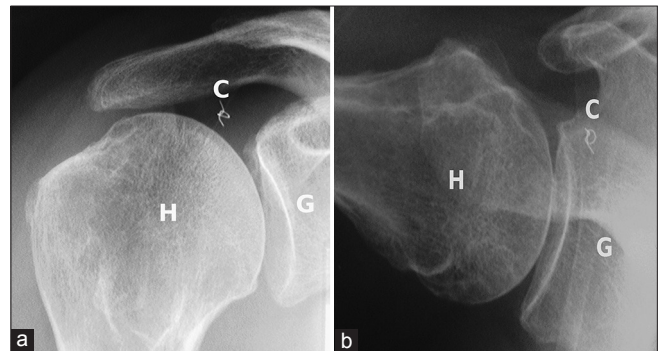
Anteroposterior (a) and axillary-lateral radiographs (b) show the medialized position of the metal marker (C), and are suggestive of failure of repair. (H: Humeral head, G: Glenoid)
